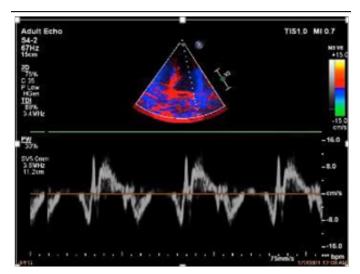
Tissue Doppler at the level of the lateral mitral ring; the diastolic function of the left ventricle can be evaluated.
